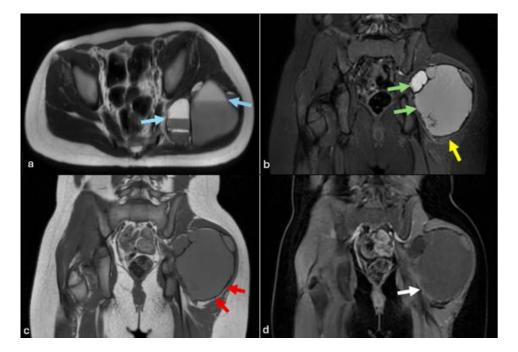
MRI sequences of the left gluteal region in a 10-year-old male patient: (a) T2-weighted image (T2W), (b) T2-STIR image, (c) T1-weighted image (T1W), and (d) post-contrast T1-weighted image.
